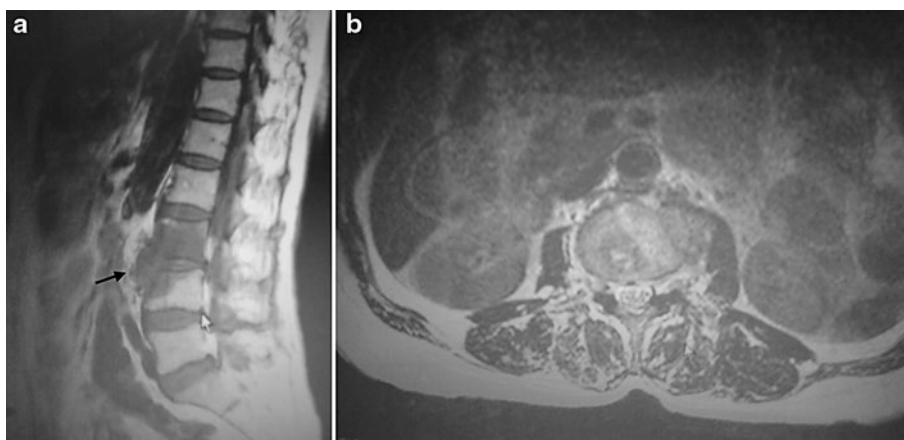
Coronal MRI of the vertebra. A right large cold psoas abscess
